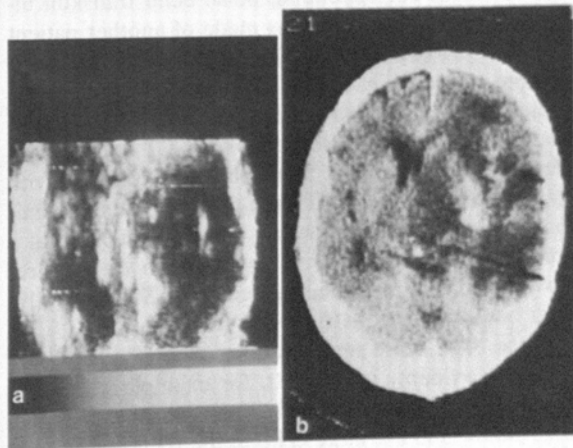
(a) UTIS and (b) contrast-enhanced x-ray CT horizontal brain scans of approximately the same region with left hemisphere shown on left side of each image. Anterior is at the top, with midline shift due to presence of a glioblastoma multiforme evident in both images.
